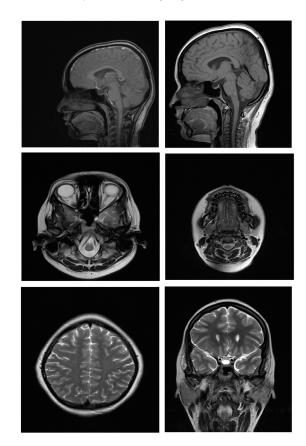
Magnetic resonance imaging (MRI) scans of the head and neck region with Ormco Inspire ICE ceramic brackets
